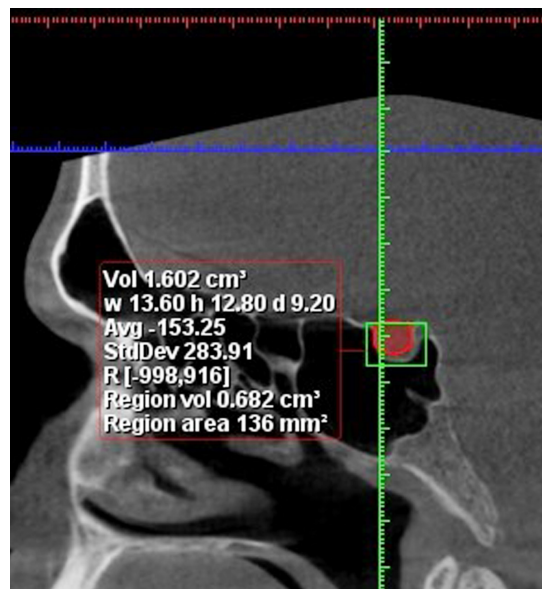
CBCT image of volume of sella turcica.
